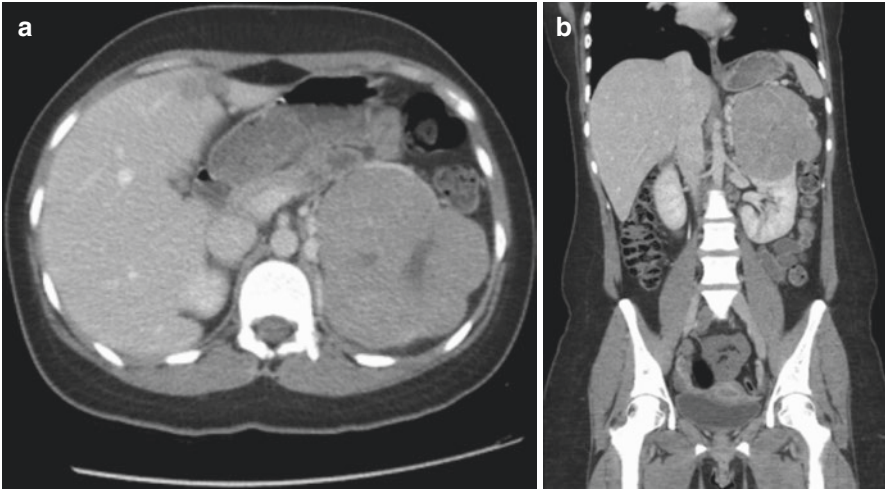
(a) axial and (b) coronal computed tomography images of a “high-complexity” lesion. R.E.N.A.L. nephrometry score = $3 + 2 + 3 + x + 2h = 10xh$
